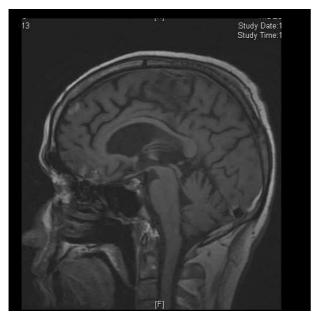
(A) Sagittal T1-weighted RM image of an alcoholic patient, with severe atrophy of corpus callosum (area= 3.9847 mm²/mm).
